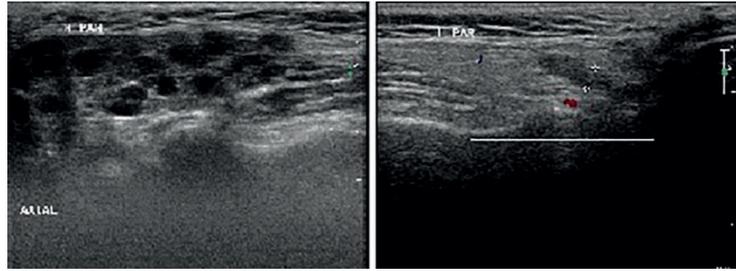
Ultrasound of parotid gland in recurrent parotitis of childhood, left side showing hypoechoic areas, right side normal
